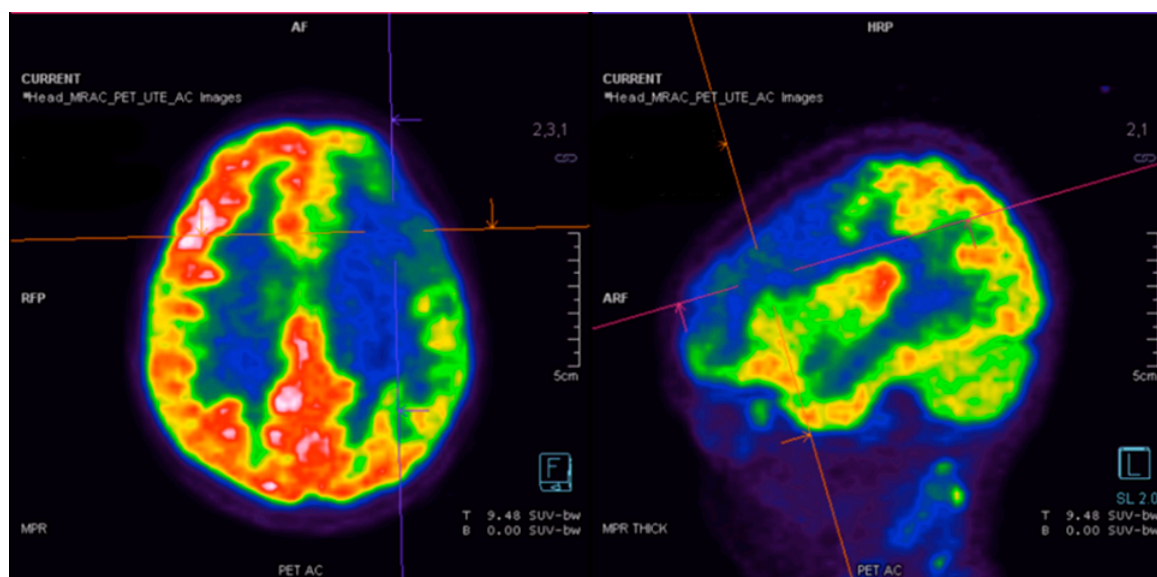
Multimodal Neuroimaging PET/MRI.
